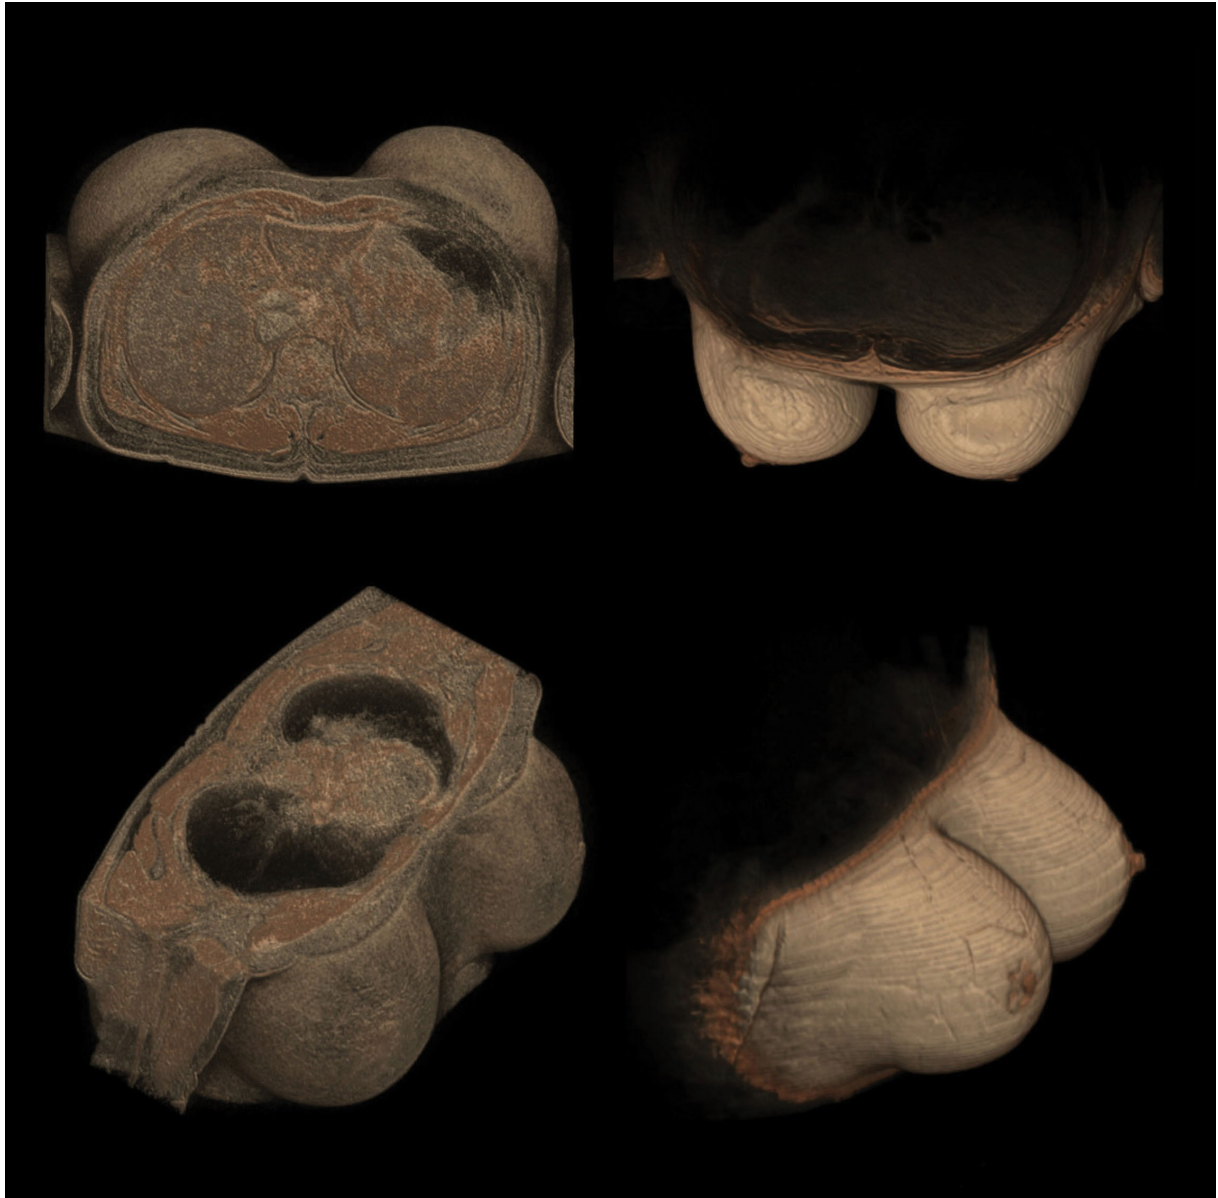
3D MRI surface rendering of the breasts in the supine (left) and prone (right) position visualizing that increased projection comes at the expense of height and width.
